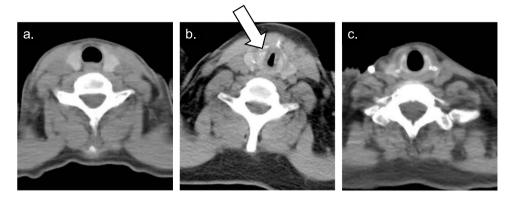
Comparison of cervical CT scans before lymphodepletion chemotherapy (a), on day 5 (b), and after improvement of the symptom (c) in case 2. Narrowing of upper airway from swelling of epiglottis and pharynx was observed (white arrow), and airway constriction rapidly improved after administration corticosteroid therapy (c).
